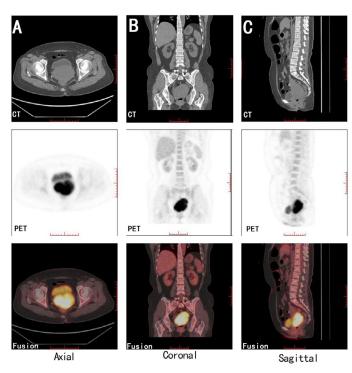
F-FDG PET/CT revealed a significantly enlarged area in the cervix consisting of a soft tissue mass ($59 \text{ mm} \times 79 \text{ mm} \times 72 \text{ mm}$) with a clear boundary with surrounding tissues and organs, SUV_{max} 18.3. A) Axial, B) Cornal and C) Sagittal.
